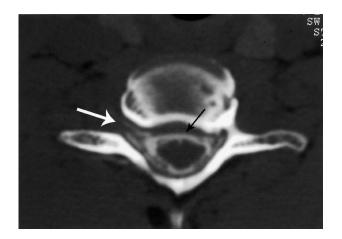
Axial computed tomographic myelogram image. Extradural contrast is seen around the right C7 nerve root sleeve (*white arrow*). The thecal sac is displaced from the posterior margin of the vertebral body (*black arrow*).
